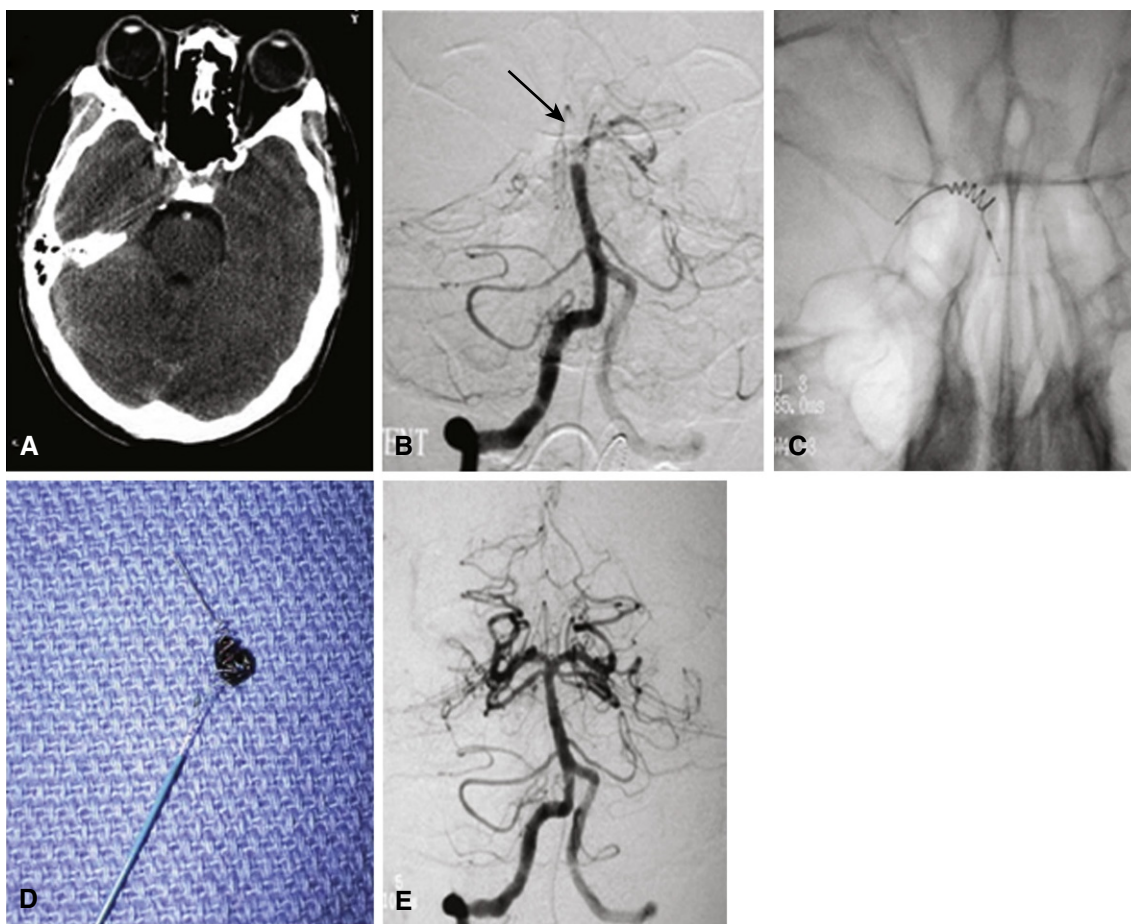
Acute basilar artery occlusion from an embolus caused by a traumatic dissection of the vertebral artery. A, Computed tomography scan demonstrates only a dense basilar artery, indicating its occlusion. B, The thrombus obstructs flow at the top of the basilar artery (arrow). C, Corkscrew-shaped clot retrieval device is seen in place on unsubtracted anteroposterior image. D, Clot was removed by means of this retrieval device. E, Flow is restored to the basilar artery, leaving the patient without neurologic deficit.
